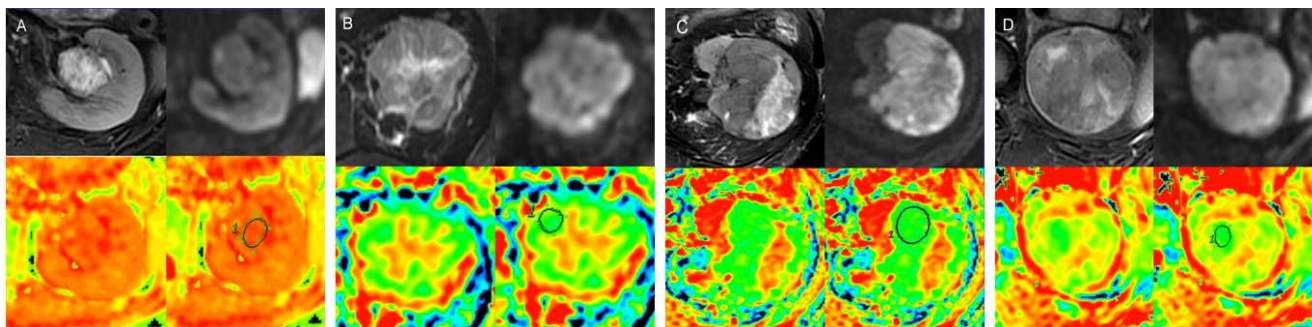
Figure A-D MR demonstration of renal clear cell carcinoma of grade I, II, III and chromophobe cell carcinoma. Every figure was composed of Axial fat-suppressed T2-WI, DWI, ADC map and ROI on ADC map. The ADC values were $2.71 \times 10^{-3} \text{ mm}^2/\text{s}$, $1.40 \times 10^{-3} \text{ mm}^2/\text{s}$, $1.11 \times 10^{-3} \text{ mm}^2/\text{s}$ and $1.17 \times 10^{-3} \text{ mm}^2/\text{s}$.
